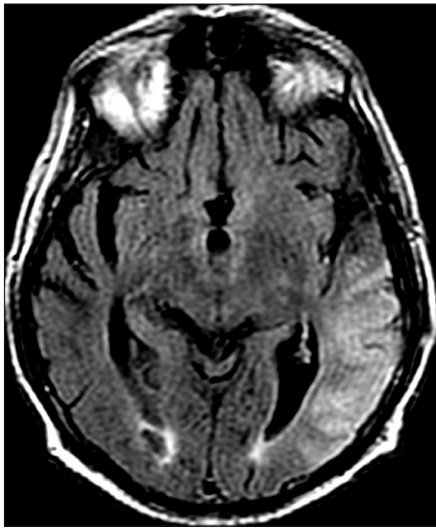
Axial FLAIR MR image obtained 24 hours after ictus, showing hyperintense edematous gyri and sulcal obliteration in the temporoparietal lobe, consistent with recent infarction.
